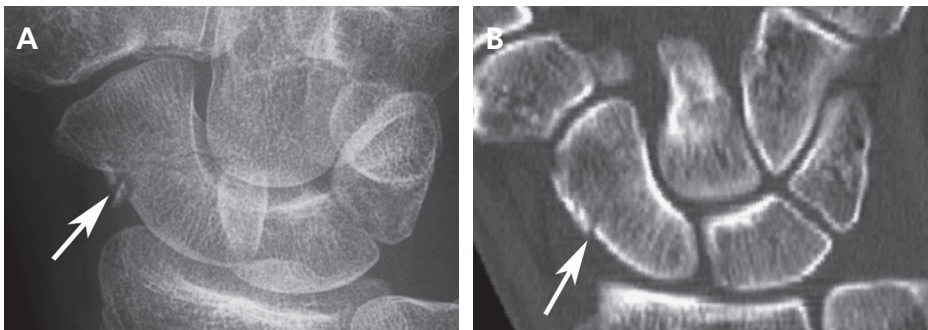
Example of radiographically comminuted and non-displaced or very minimally displaced fracture on radiographs (A) and CT (B) that was arthroscopically displaced and unstable.
